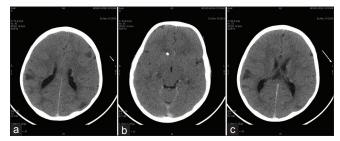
(a-c) CT images show foci of hyperdensity along the subependymal lining of lateral ventricle suggestive of subependymal nodules, multiple cortical, and subcortical hypodensities- cortical tubers and showed right periventricular calcification
